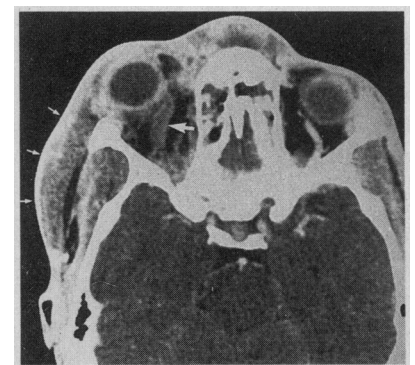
Axial computed tomographic scan of the brain (April 5, 1989) shows increased right-sided facial and orbital swelling and proptosis (small arrows) and thrombosed right superior ophthalmic vein (solid white arrow).
